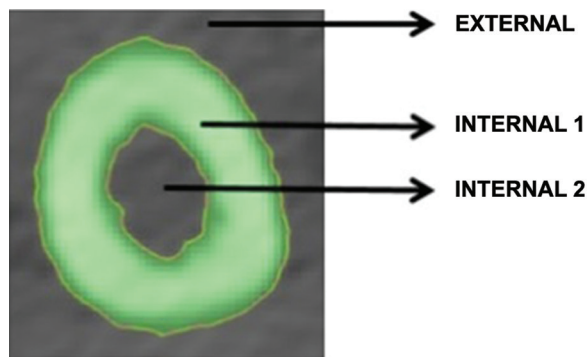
Humeral CT sections measurement (length and diameter), cleaning of CT medullary canal for its measurement (8 cm distal, 6 cm proximal). Creation of polylines, curves and measurement. Software: Mimics, 3-matic (Materialise Inc., Leuven, Belgium).
